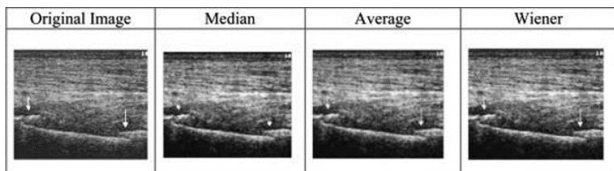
Fibula fracture ultrasound image using Median, Average and Wiener.
